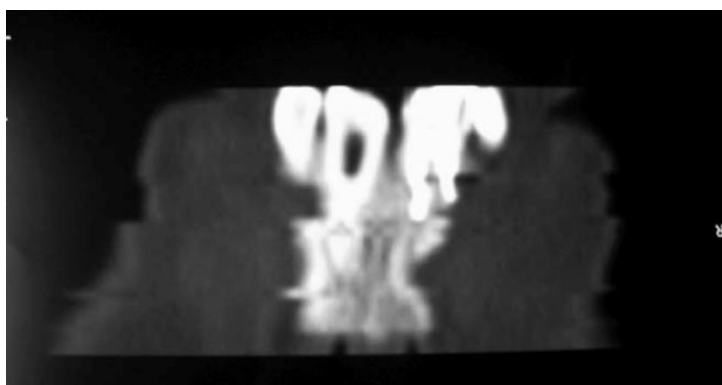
CT examination; longitudinal.
